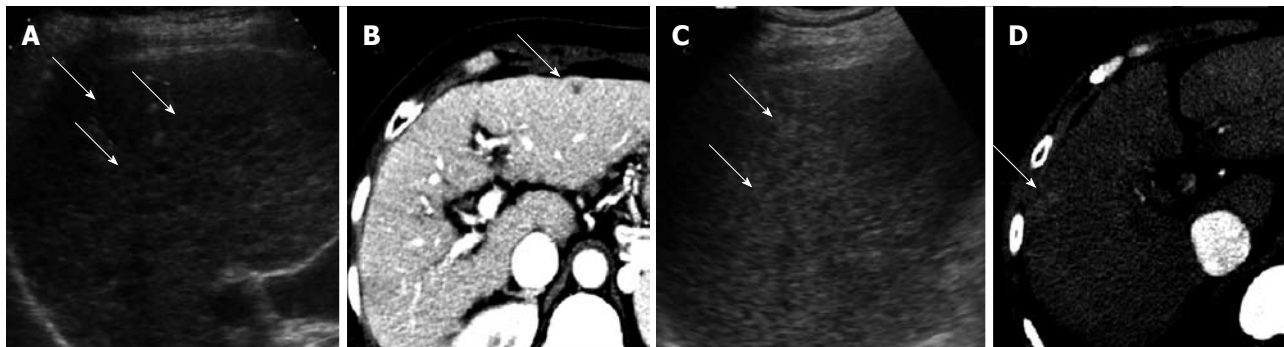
Representative cases according to ultrasonography and computed tomography findings. A: Ultrasonography shows scattered sub-centimeter-sized low echoic nodules; B: Arterial phase computed tomography (CT) scan shows a 5 mm sized low attenuated nodule in left lobe of liver; C: Ultrasonography shows a 7 mm sized hyperechoic nodule in right lobe of liver; D: Arterial phase CT scan shows a 5 mm sized high attenuated nodule in right lobe of liver.
